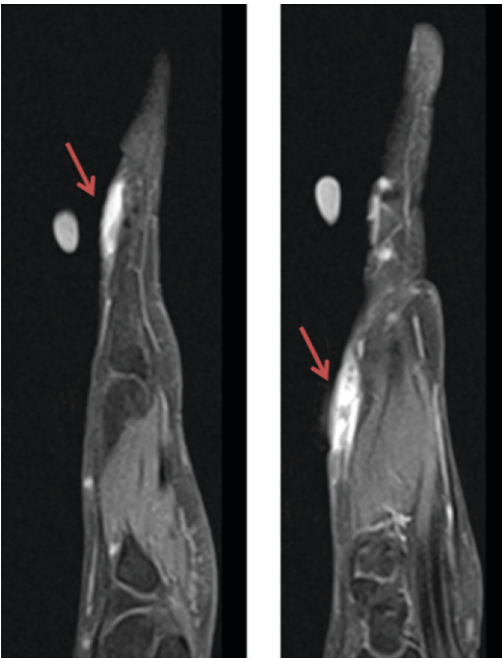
MRI of the right hand showing cutaneous and subcutaneous inflammation without evidence of abscess or septic arthritis.
